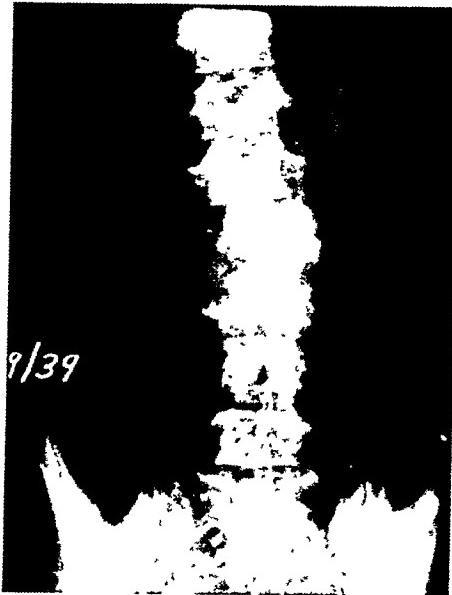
Anteroposterior roentgenograms of lumbar spine of A. C., August 19, 1939, the day following attempt at closed reduction.
